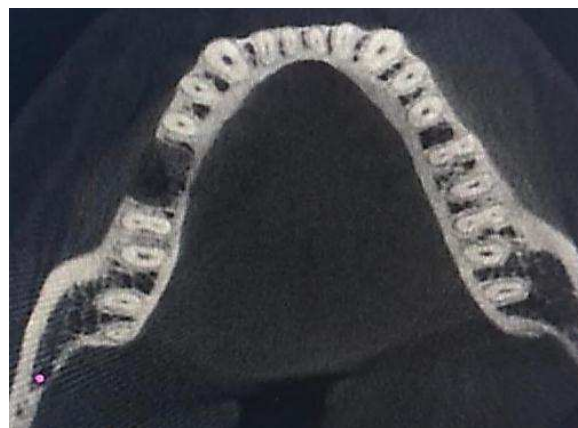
CBCT axial view showing the orifice of canals
